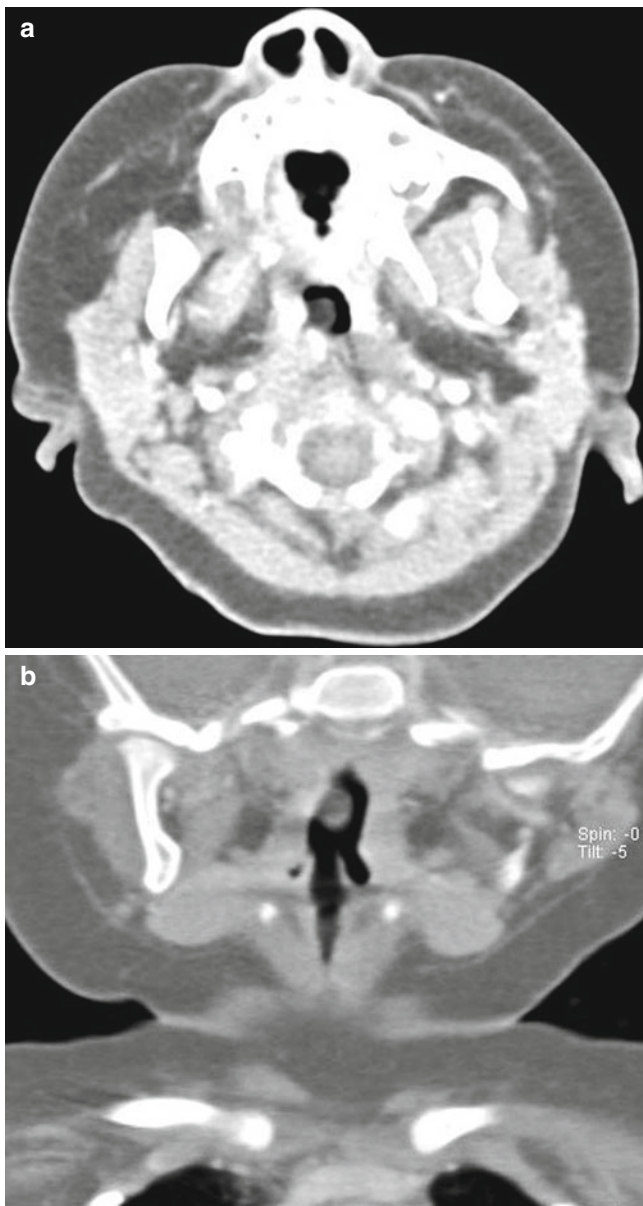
Pharyngeal cyst in a 4-month-old infant. (a, b) CT scans of the neck show a small unilocular thin-walled cyst arising from the right lateral wall of the oropharynx
